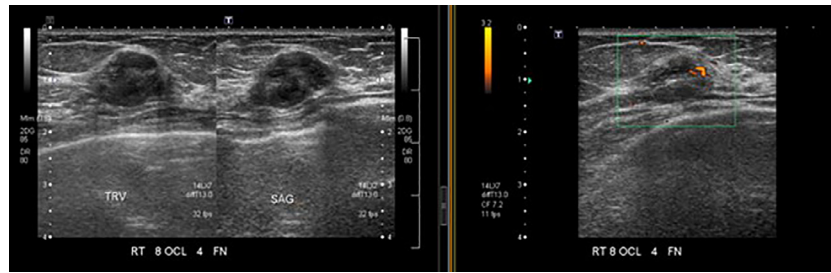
Ultrasound: Ultrasound of the right breast demonstrates an ovoid circumscribed hypoechoic mass, corresponding to the biopsy-proven melanoma metastasis.
